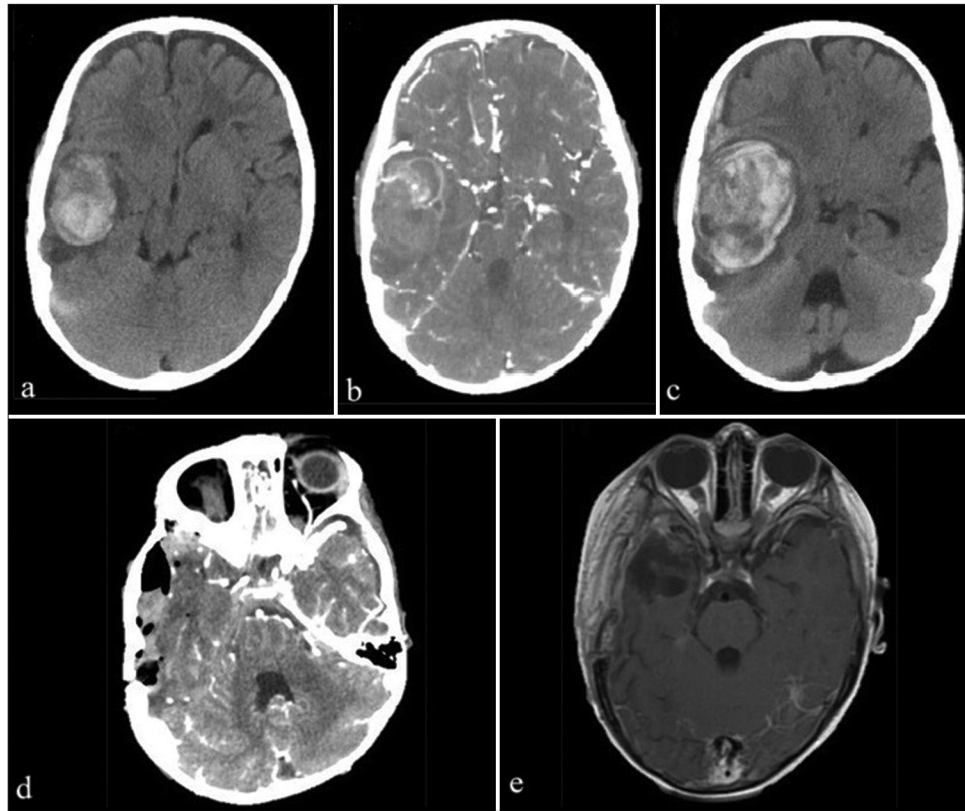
Brain scans of Case 12. (a and b) Initial computerized tomography (CT) scans show hemorrhagic brain tumor in the right temporal lobe; (c) repeat CT scan 3 days later shows expanding hemorrhage with midline shift, causing conscience deterioration (Glasgow comma scale of 4), warranting emergency surgery; (d) immediate postoperative CT scan confirms gross total resection and hemostasis; and (e) follow-up magnetic resonance imaging at 3 months shows no recurrence. The patient had an uneventful recovery for 2 years after surgery.
